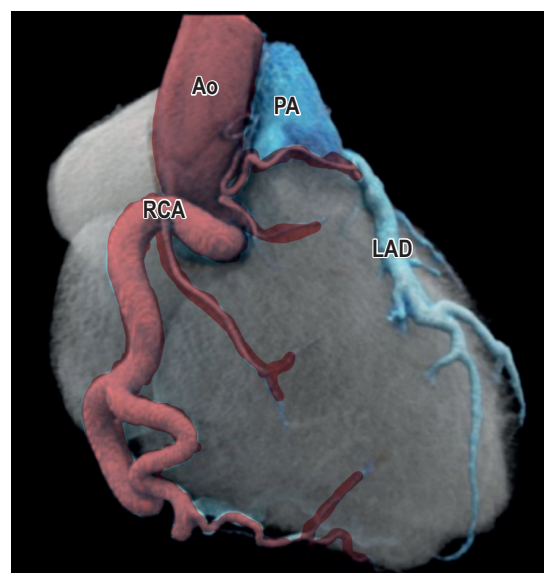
Coronary CT reconstruction showing the right coronary artery with its usual origin from the aorta and the left anterior descending artery with its anomalous origin from the pulmonary artery.
